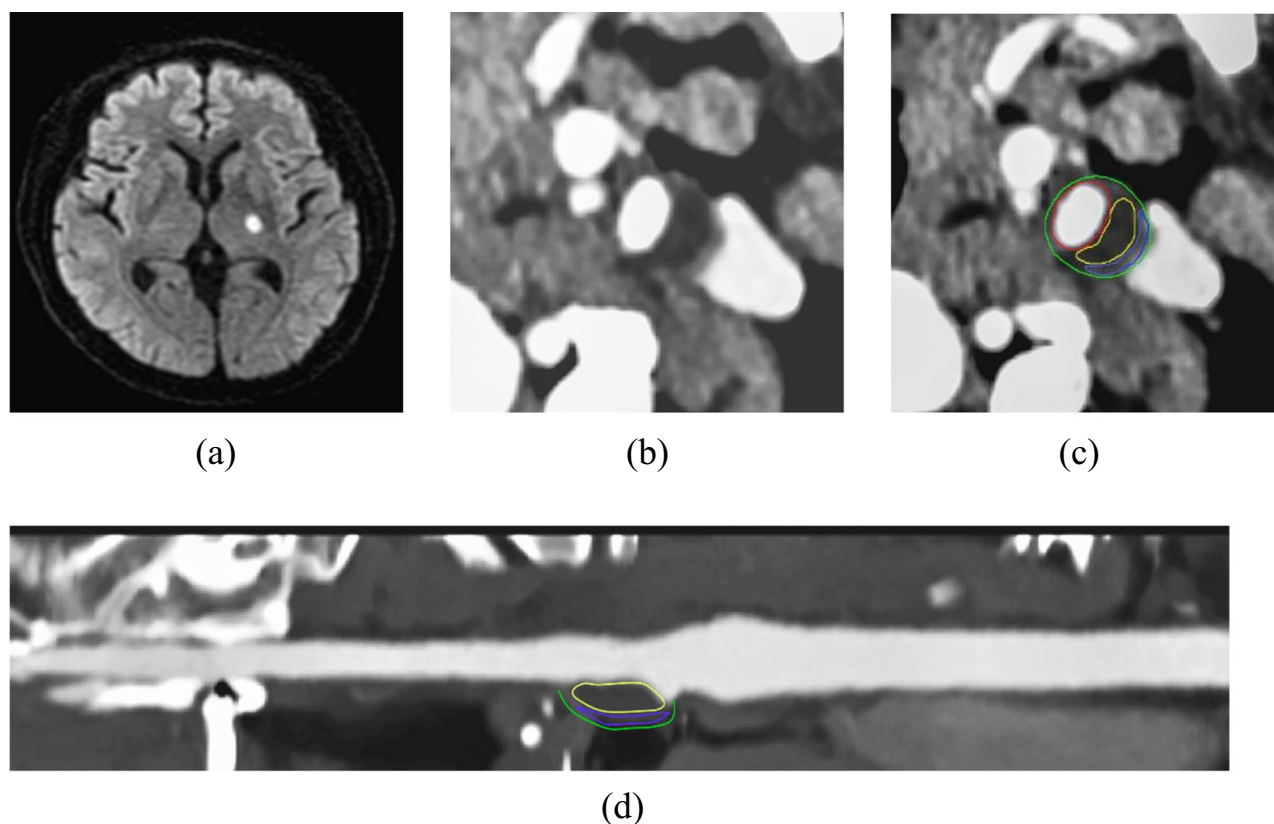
A 69-year-old man diagnosed with ischemic stroke in the left basal ganglia region (shown in the diffusion-weighted images, a) with numbness and weakness in the right extremities had a plaque with NRS at the left common carotid artery identified on CTA (b, c). The yellow round demonstrates the low attenuation area of the plaque surrounded by a high-attenuation rim (purple round), and the blue area represents the lumen filled with contrast. The reconstruction image (MPR) was shown as picture (d)
